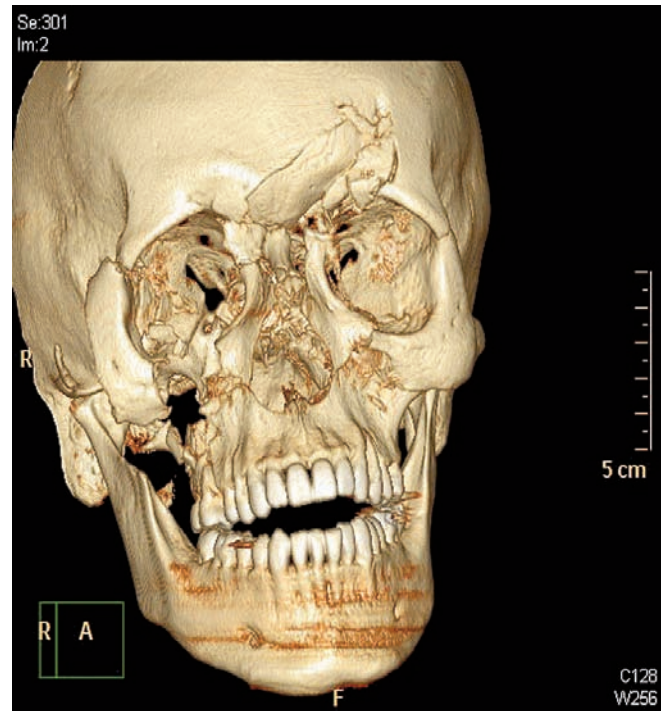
3D CT demonstrating craniofacial injury
